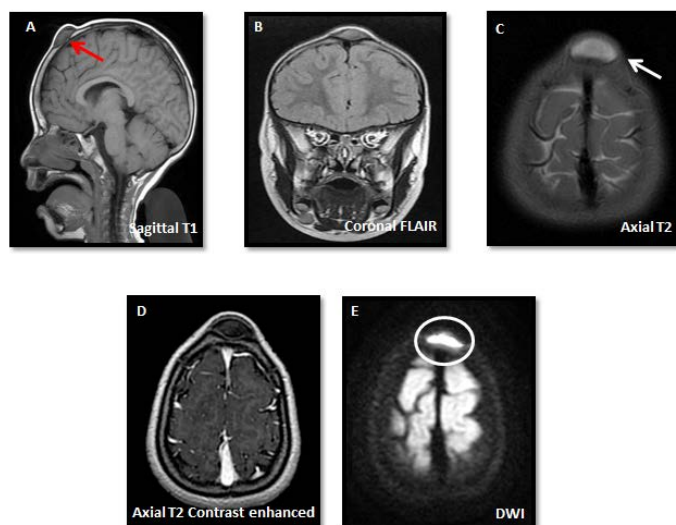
MRI images showing features of a confirmed intradiploic epidermoid cysts such as hypo-intense signal on sagittal T1-weighted with thinned dura (red arrow) as well as coronal flair (B), Hyper-intense homogenous signal on axial T2 as demonstrated by the white arrow as well as a clear intense signal on DWI which sets it apart from other similar lesions (white circle).
